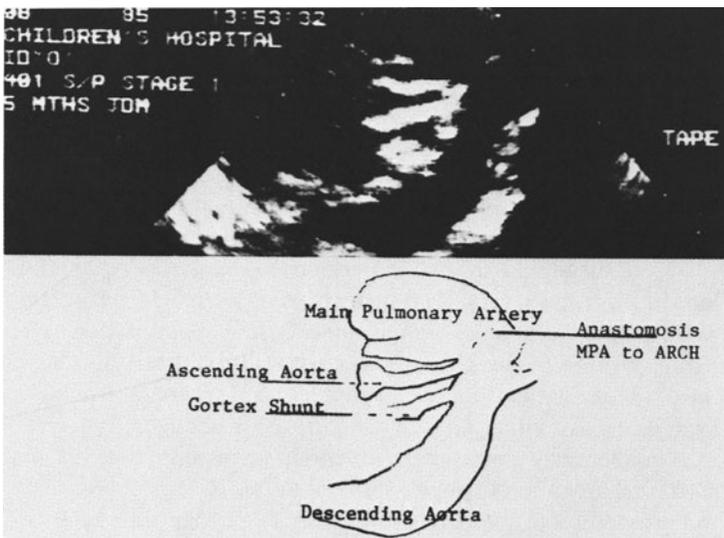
New aortic arch from the high left parasternal view.
